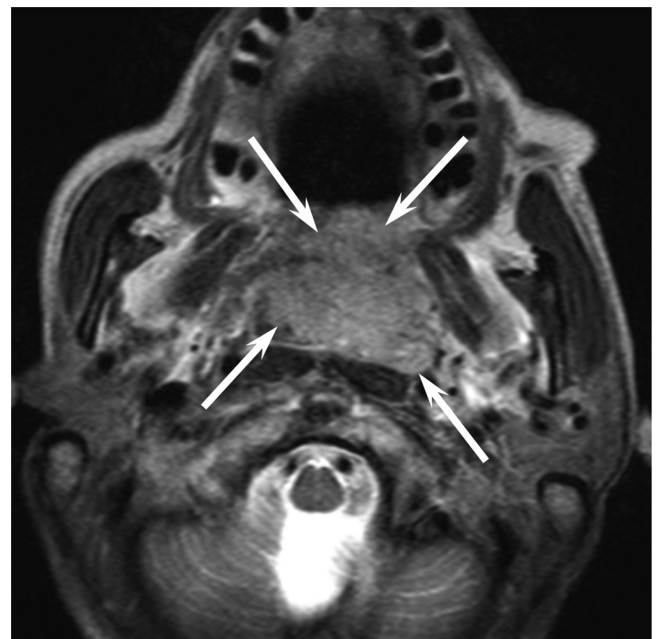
A 50-year-old woman with polymorphous low-grade adenocarcinoma of the whole palate. Axial T2-weighted image shows a heterogeneous, mixed iso- to hyperintense lesion (arrows). Metastasis to the left retropharyngeal node is found (arrow head).
